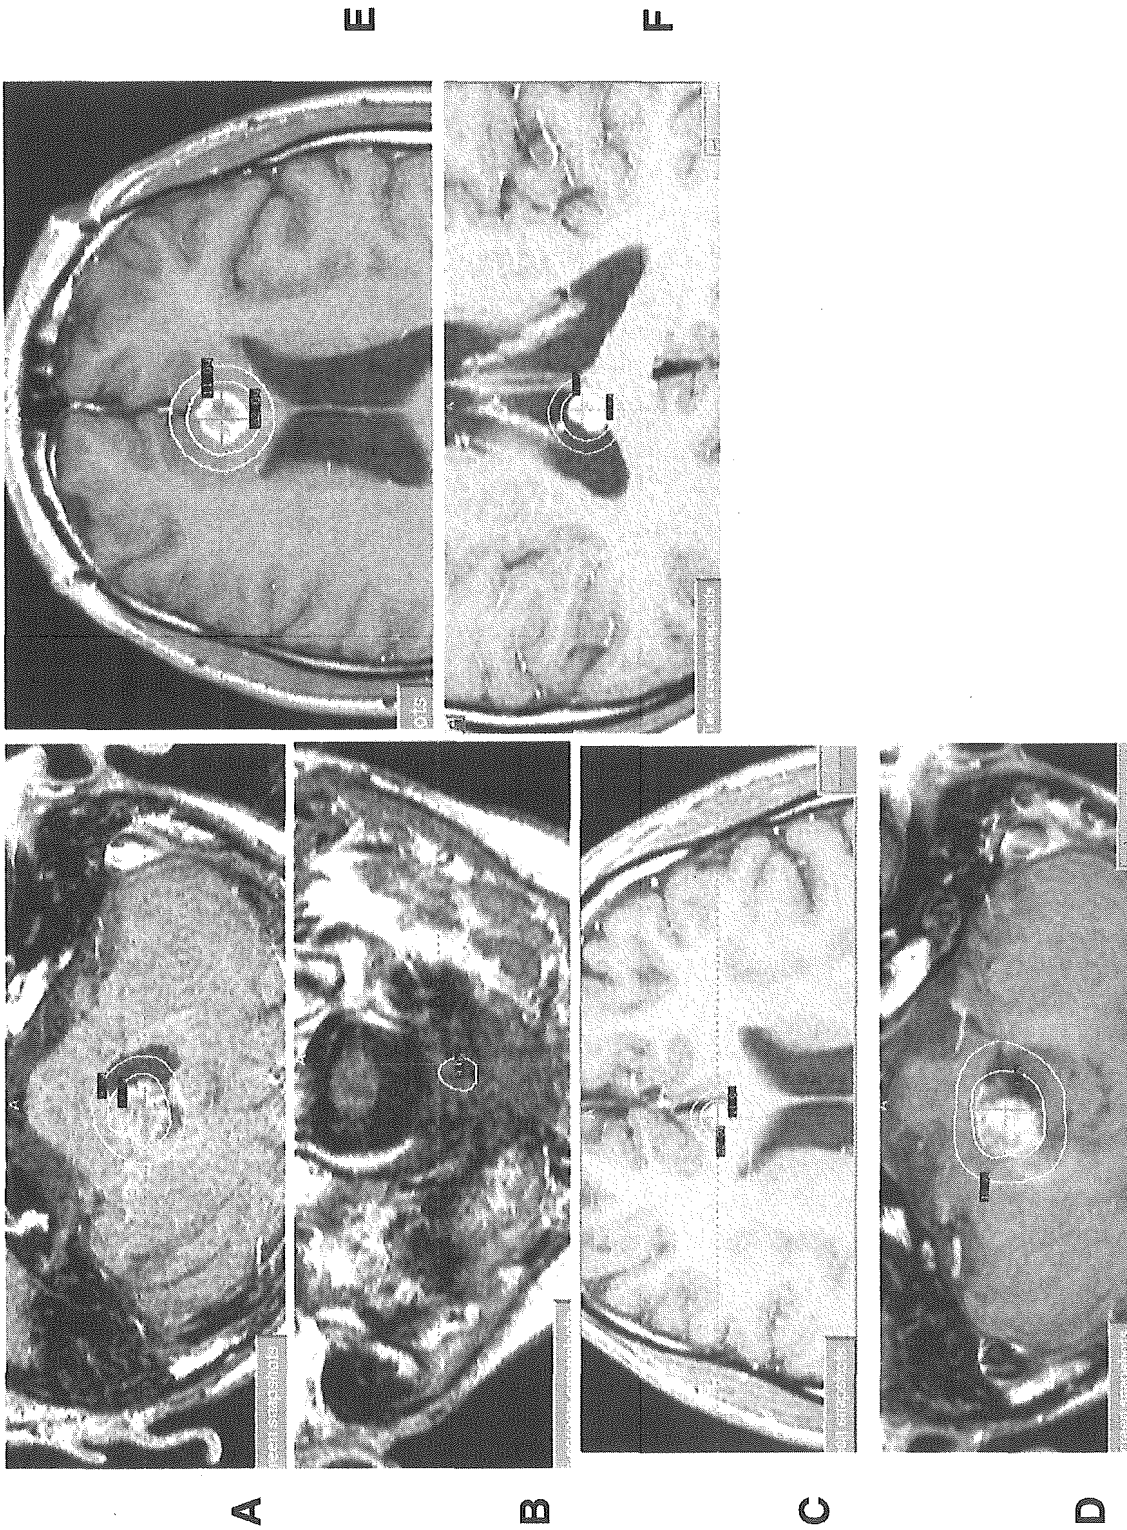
Case 2: Axial T1-weighted MR images with gadolinium-diethylenetriaminepenta-acetic acid displayed on workstations running the Leksell GammaPlan program. (A) First Gamma knife (GK) radiosurgery for local recurrence. (B) Second GK radiosurgery for local recurrence. (C) First GK radiosurgery for dissemination in the corpus callosum. (D) Third GK radiosurgery for local recurrence. (E) Second GK radiosurgery for dissemination in the corpus callosum. (F) GK radiosurgery for dissemination in the right lateral ventricle
